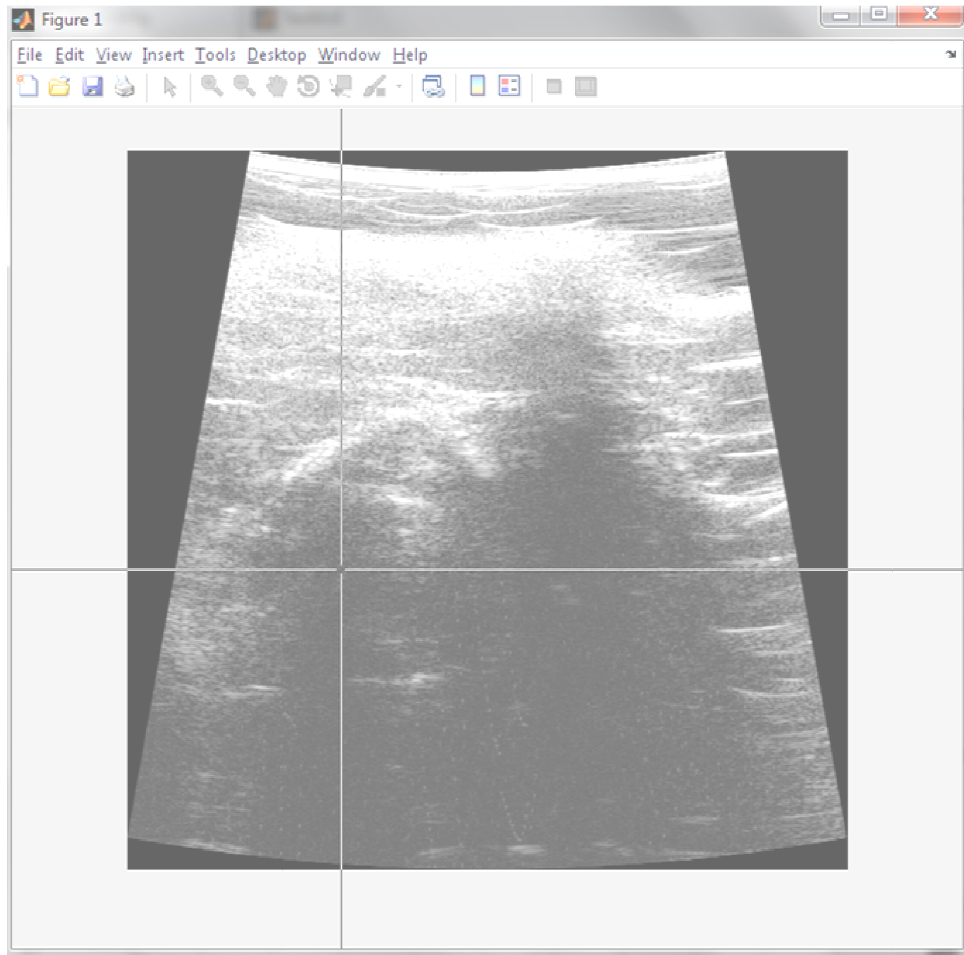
Selecting Quadrilateral from Ultrasound Image
